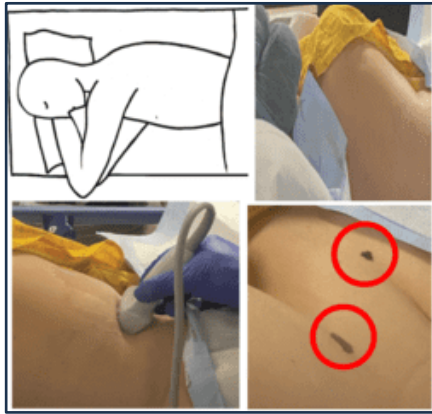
Patient positioning (lateral decubitus or supine), ultrasound of the pleural space and marking of appropriate IPC insertion sites.<sup>37</sup>
